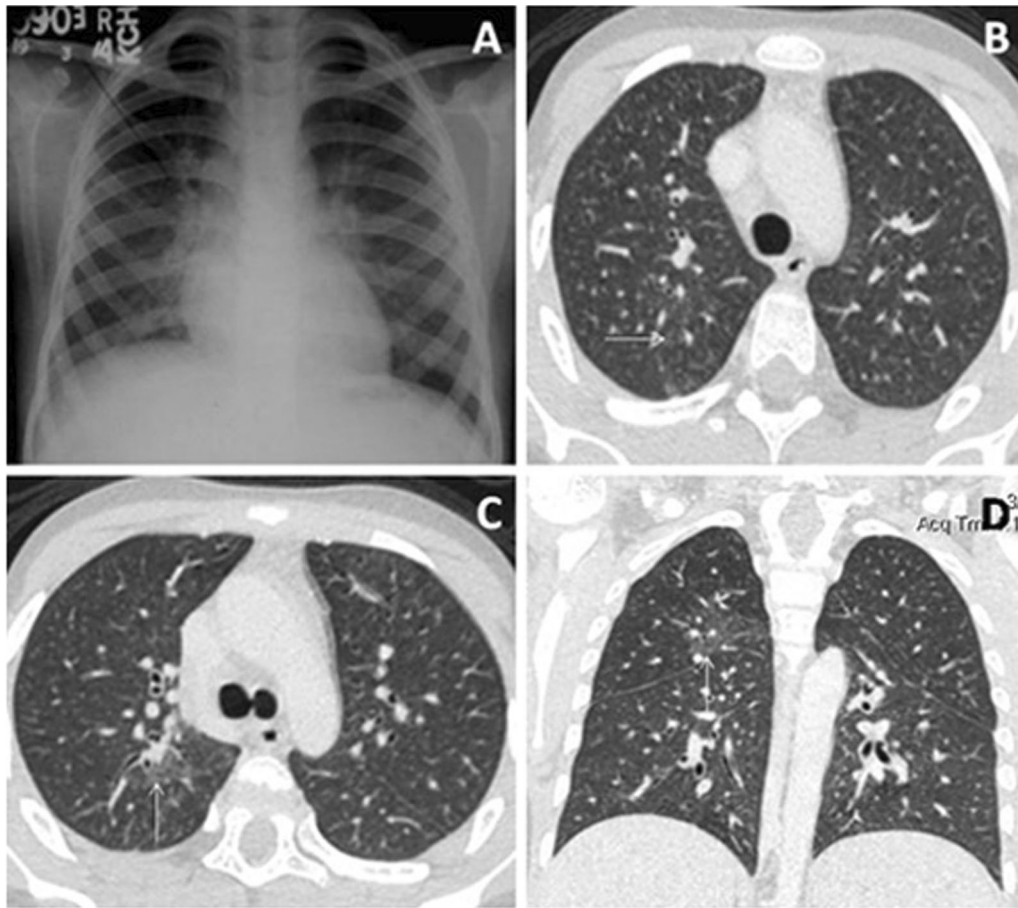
Tubercular Infection. Chest radiograph (A) was normal in this 12-year-old HIV-positive male, who presented with fever since 4 days. CECT chest (B,C,D) was then done, which showed subsegmental area of GGO along with ill-defined centrilobular nodules in RUL, predominantly involving posterior segment (arrows in B,C). Ultrasound abdomen revealed multiple mesenteric lymph nodes, some of which showed central necrosis (not shown). Sputum could not isolate any microorganism, BAL isolated *Mycobacterium tuberculosis*. CD4 count was 150 cells/cu.mm. On basis of these findings, ATT was started and patient showed clinical improvement within 10 days of start of ATT
